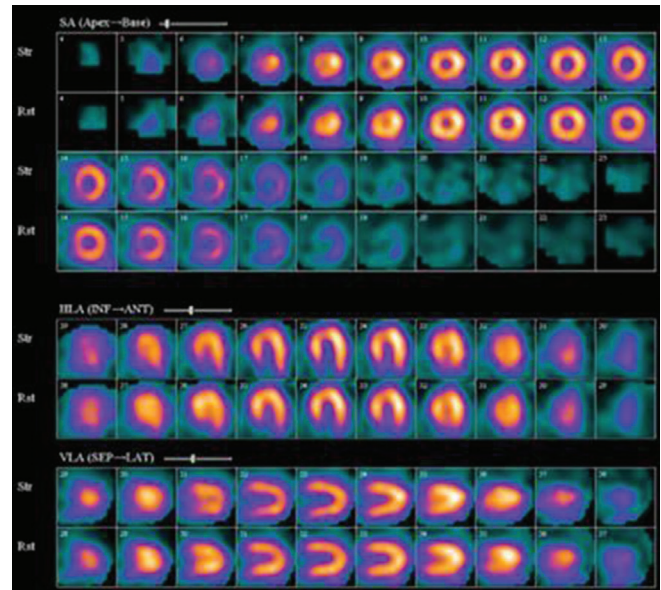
Sample SPECT-MPI image without CAD.
